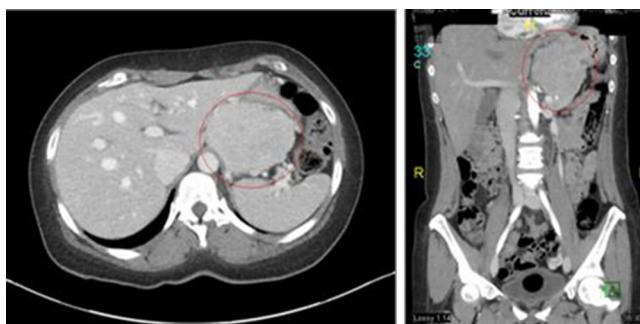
Computed Tomography of the abdomen and pelvis (axial and coronal) showing a large gastric mass.
